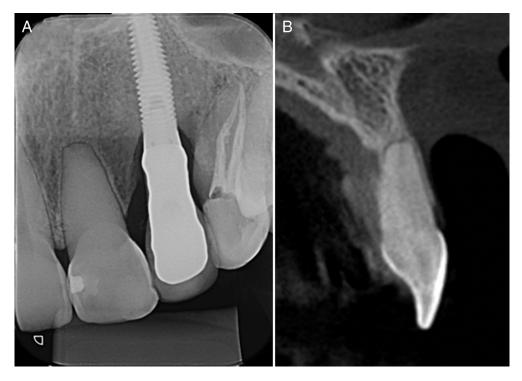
(*A*) A preoperative radiograph showing both the pulp chamber and the root canal completely calcified. (*B*) Sagittal reconstruction showing that only the last 2 mm were visible in the apical third of the root.
